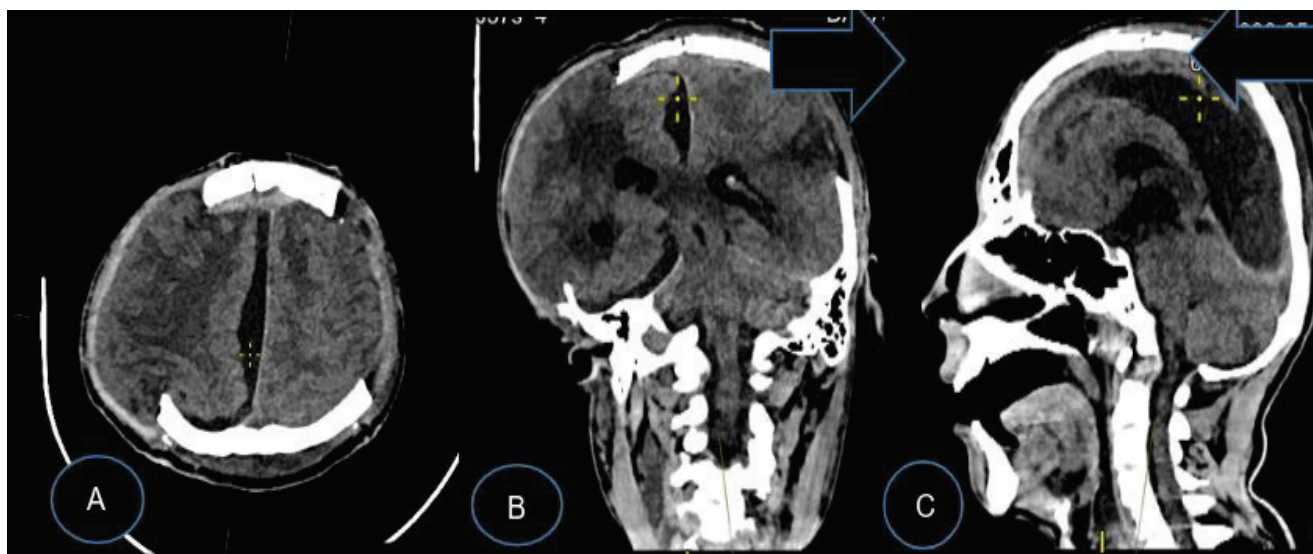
a) Postoperative axial CT scan, bilateral right and left decompressive craniotomy, b) coronal image with expansion of the ventricles due to the presence of CSF, c) sagittal image with the presence of hydrocephalus
